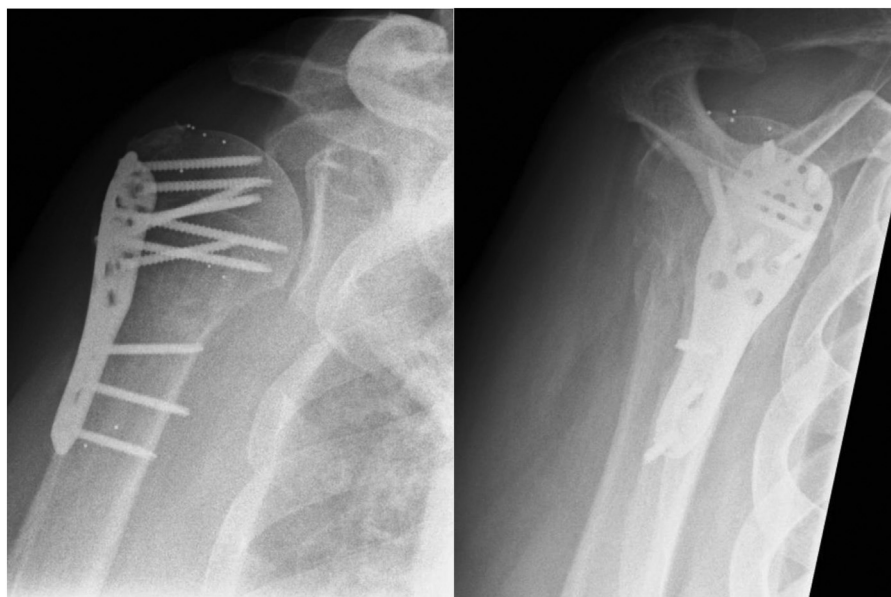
Representative postoperative x-rays from 1 patient demonstrating the Winsta proximal humerus angular stable locking plate.
